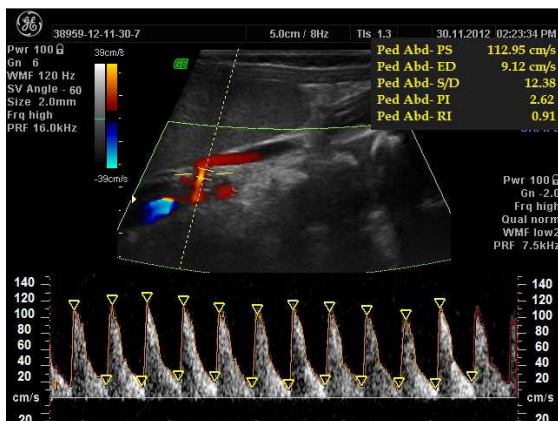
Color Doppler examination of the SMA flow indices in a neonate aged 29 weeks who later developed NEC (PSV 112 cm/s, EDV 9 cm/s, RI 0.9, PI 2.6)
